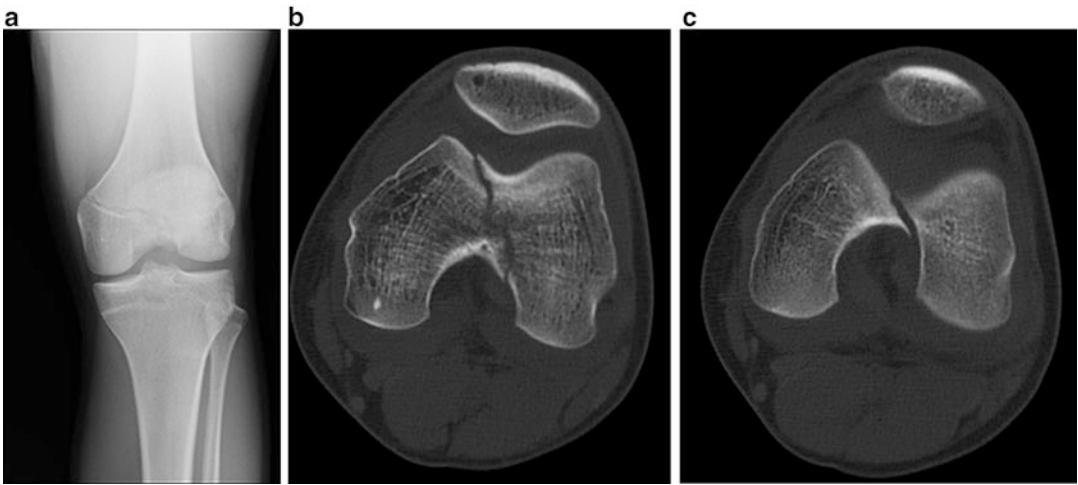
(a) Radiograph suggesting non-displaced Salter-Harris III fracture in a 17-year-old hockey player following a moderate-energy leg-to-leg blow. (b, c) CT
